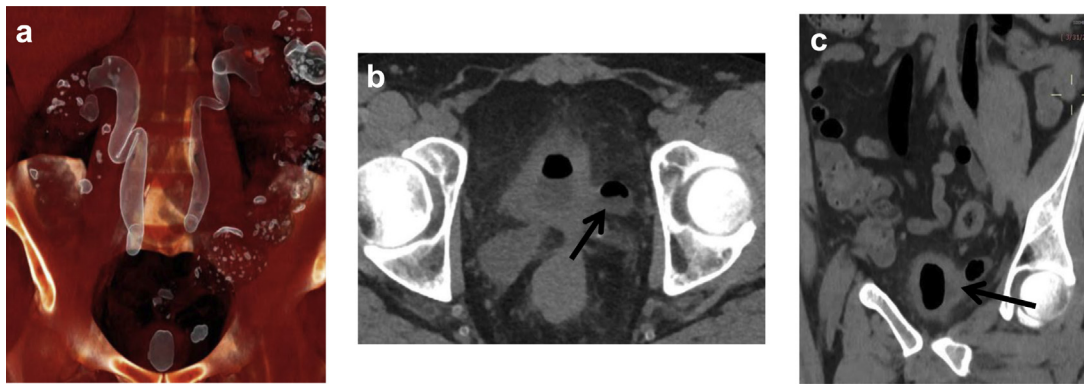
(a) In this coronal Multi Planar Volume Rendered (MPVR) Reformation CT scan, the white highlighted areas represent air in the collecting system. The bladder and ureters all have abnormal amounts of air compared to the expected air seen in the descending and ascending colons. (b) In the axial cross-sectional and coronal views (c), air in the collecting systems is seen once again. In addition, both pictures reveal the likely position of the colovesical fistula between the bladder and colon (marked with black arrows).
